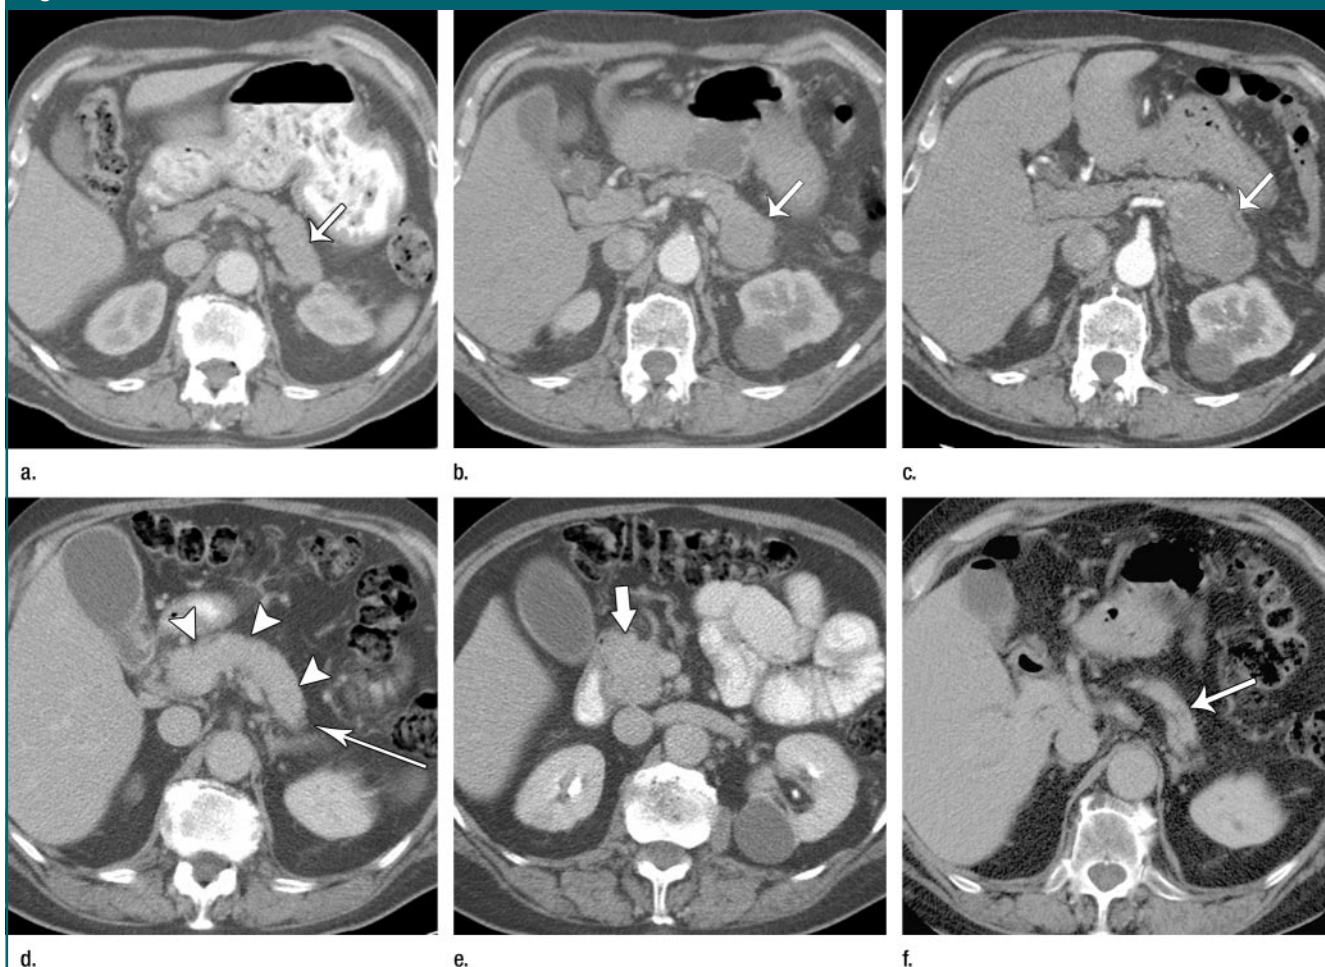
Sequential axial CT images through pancreas in 72-year-old man who eventually developed atrophy of the pancreas after CST. (a) Image from initial examination shows mild fullness in the tail (arrow) that worsened gradually over an 8-month period on (b, c) images from two subsequent CT examinations (6 and 8 months from baseline, respectively). (d) The disease in the pancreas then evolved over next 18 months into diffuse swelling (arrowheads), retraction of the tail (arrow), and loss of lobularity. The patient had jaundice and pruritus at this stage. (e) The head of the pancreas at this stage (18 months from baseline) also appears enlarged (arrow), but the focal changes in the tail noted on prior studies have resolved. (f) A course of CST was given that resulted in complete resolution of pancreatic swelling 22 months from baseline, with changes of atrophy in the pancreas (arrow).
